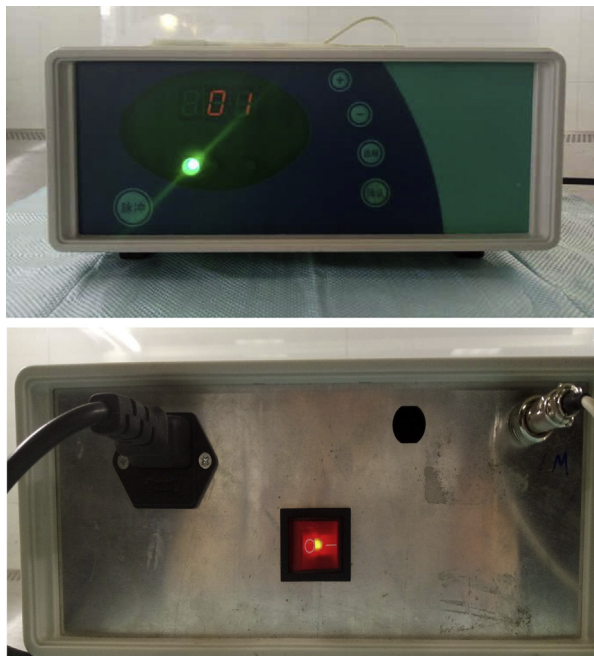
Ultrasound therapy device.
